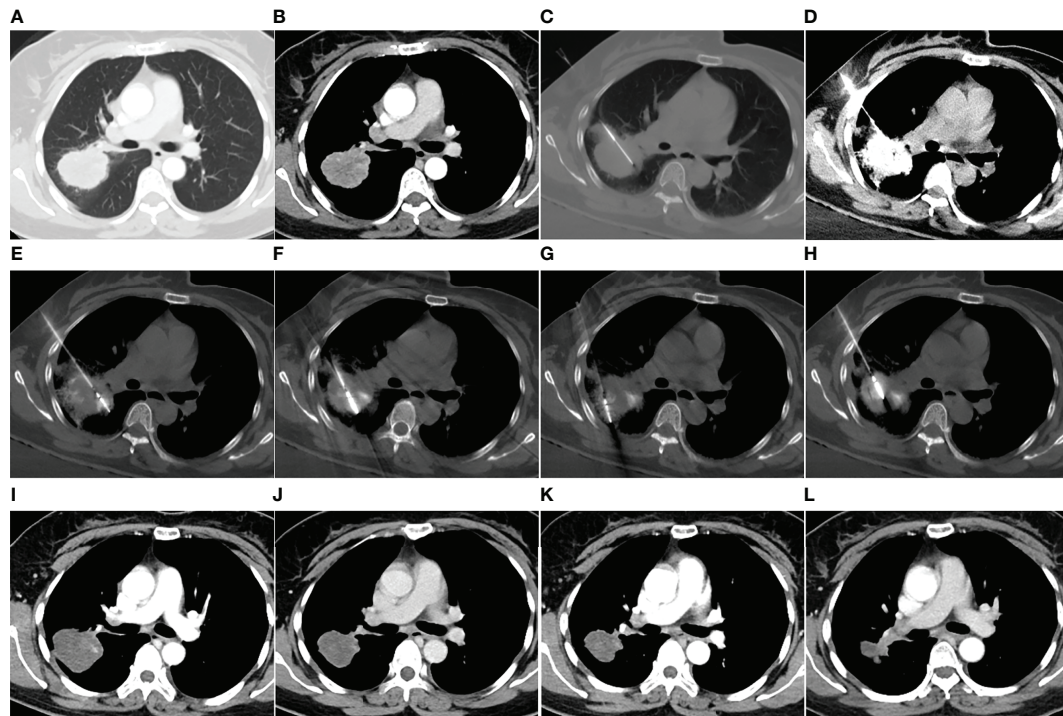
MWA + ITC treatment of a large lung adenocarcinoma in the right upper lobe of a 48-year-old woman. Enhanced CT scan in the pulmonary (A) and mediastinal window (B) showing a nearly round mass with a diameter of 5.0 cm close to a large hilar vessel. (C) Insertion of a 21-gage Chiba needle into the side of the tumor near the hilar vessel. (D) Injection of 40 mg cisplatin aqueous solution containing 2 mL iodixanol into the mass, and diffusion of the agent over the entire tumor displayed by high-density iodixanol. (E–H) MWA using two antennae with multisite and multisession insertions. (I) Enhanced CT scan at 1-month follow-up showing complete necrosis. (J–L) Enhanced CT scan at 3-, 9-, and 18-month follow-up after MWA + ITC showing gradually involuting fibrosis of the necrotic zone and no local recurrence. MWA, microwave ablation; ITC, intratumoral chemotherapy; CT, computed tomography.
